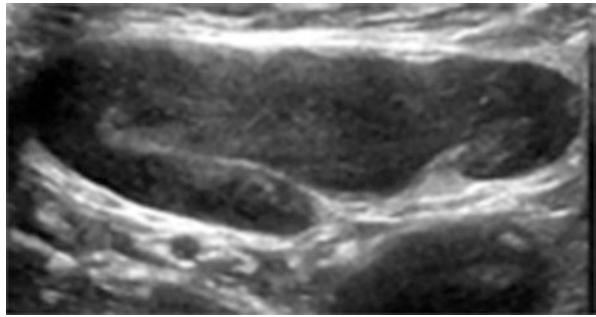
An 8-month-old with circumscribed, hypoechoic, and heterogeneous mass in the upper outer quadrant of the left breast. Color Doppler shows high flow in the entire lesion with a vascular pedicle, consistent with arteriovenous malformation
